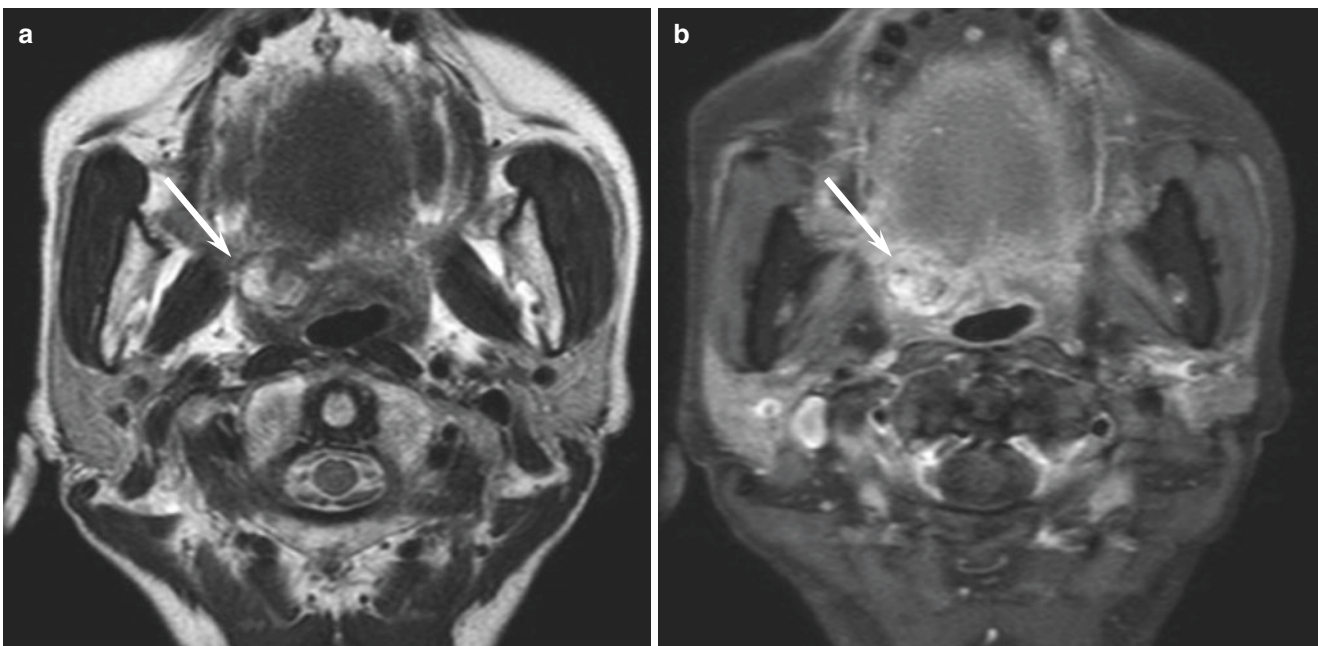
A 70-year-old woman with adenoid cystic carcinoma of the right soft palate. (a) T2-weighted image shows a well-demarcated, heterogeneously hyperintense lesion (arrow). (b) Fat-suppressed
